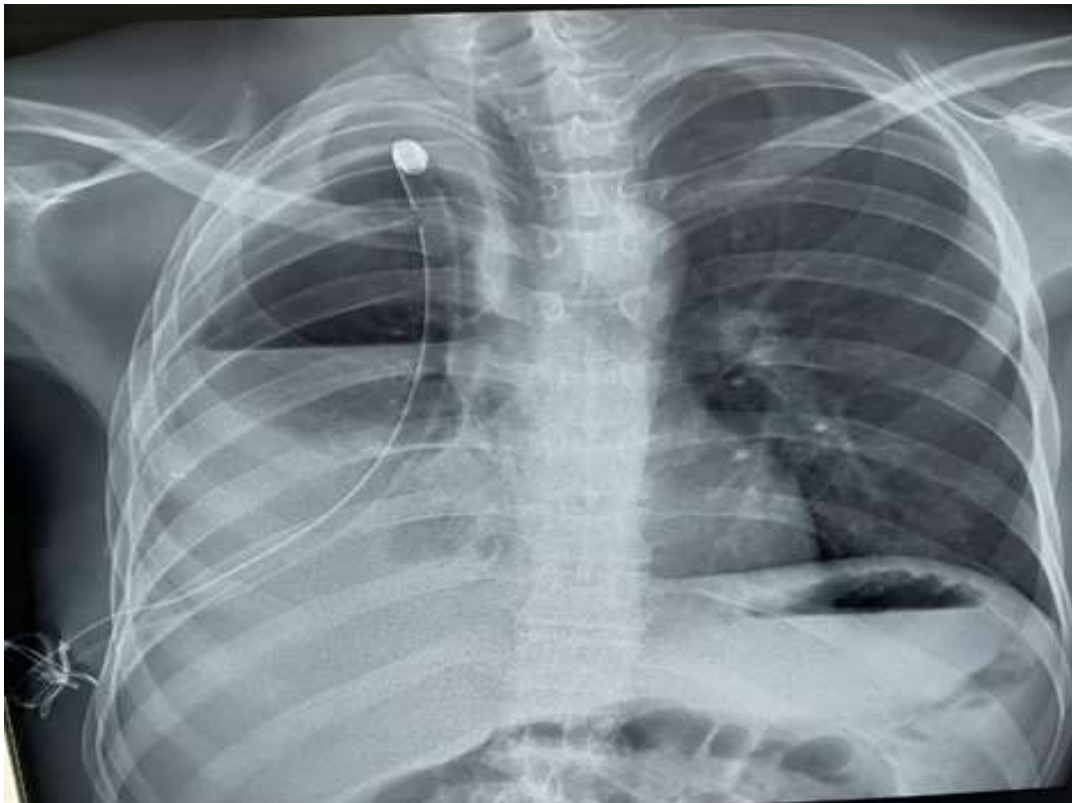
X-Ray showing a right hydropneumothorax
